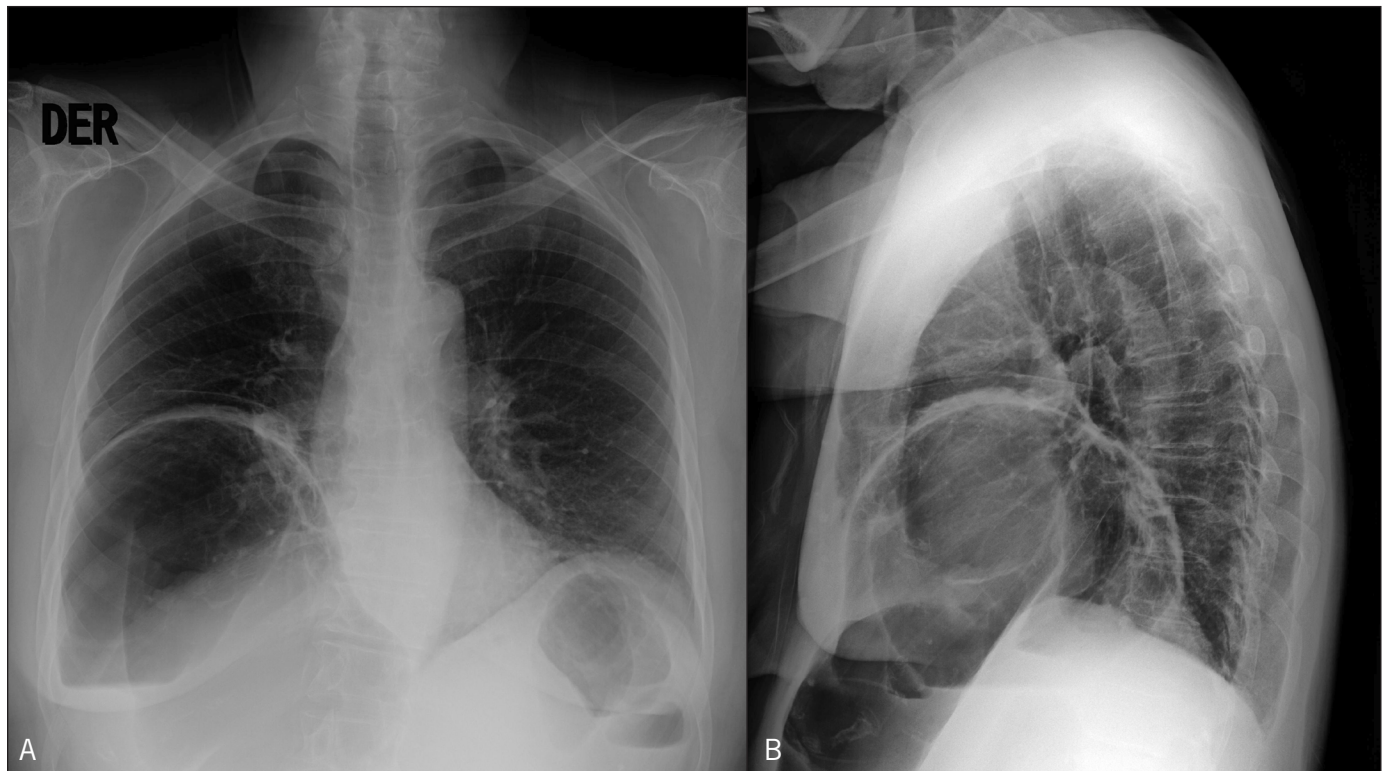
(A) Anteroposterior and (B) lateral chest radiographs showing air in the right upper quadrant due to hepatodiaphragmatic interposition of the colon, elevation of the right hemidiaphragm, and inferior and medial displacement of the liver.
